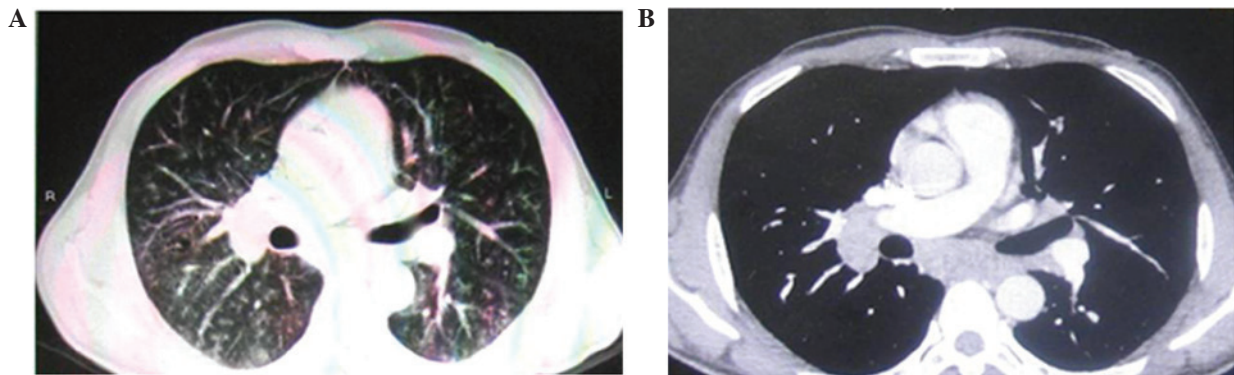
Contrast-enhanced computed tomography scan of case 2, revealing multiple nodules in both lungs, as well as the hilum and mediastinum. (A) Lung and (B) mediastinal window.
